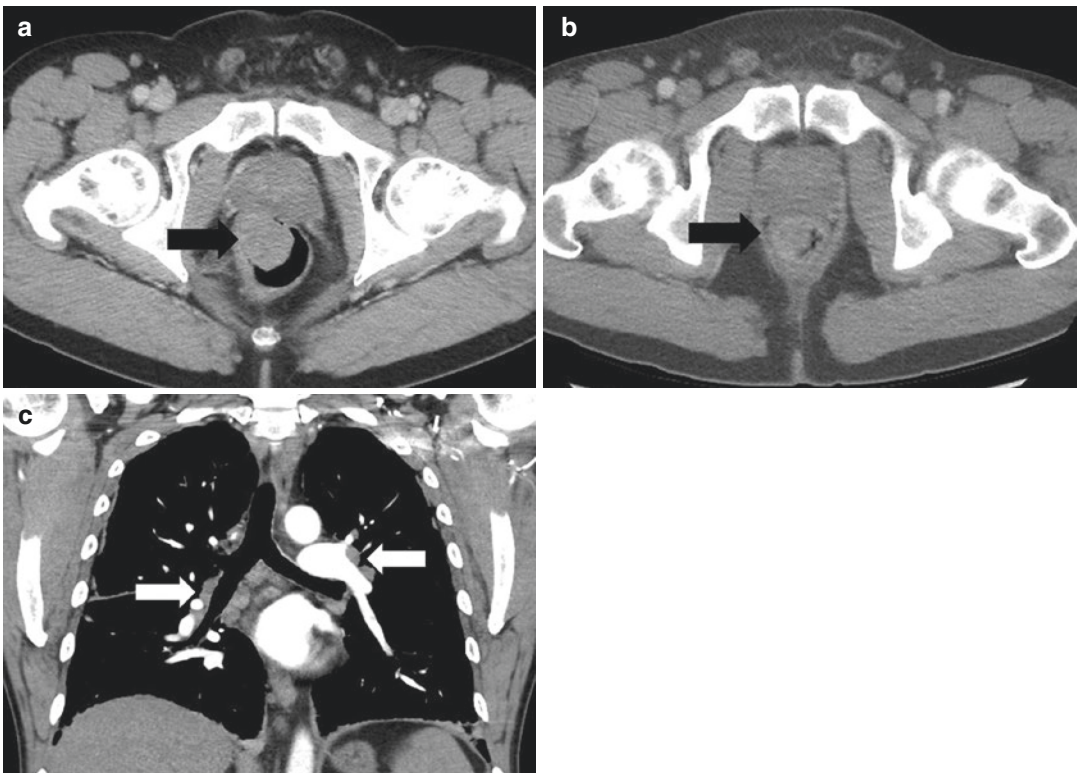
A 51-year-old man with rectal melanoma treated with ipilimumab and nivolumab combination therapy. (a) Baseline CT shows a large intraluminal mass in the rectum (arrow) representing rectal melanoma. (b) Follow-up CT after 1 month of therapy shows significant decrease of the rectal mass (arrow). (c) However, chest CT after
